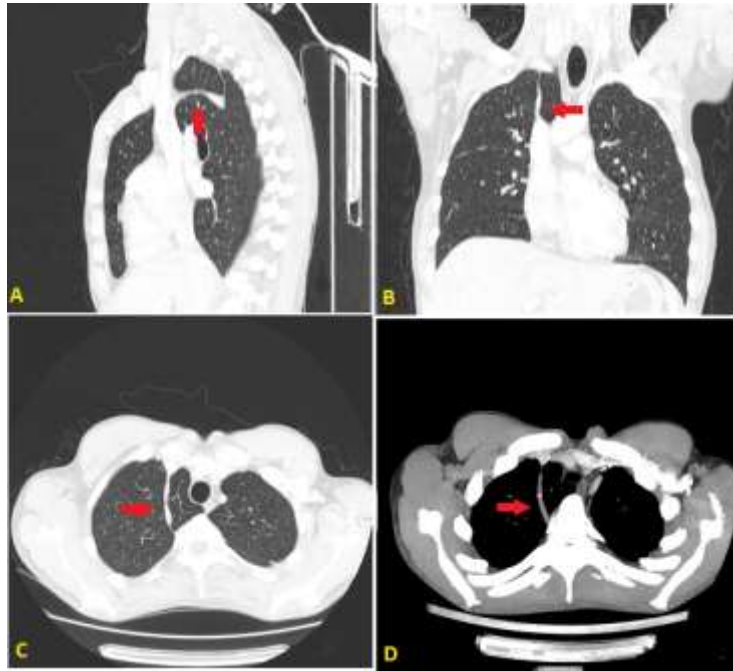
(A) sagittal section-CT; (B) coronal section-CT; (C) axial section-CT on pulmonar window; axial section-CT (D) on mediastinal window shows a thin curvilinear density seen in the upper right lung, convex towards the chest wall at its base is the azygos vein which can be seen as a teardrop-shaped structure (red arrows) which corresponds to an azygos fissure
